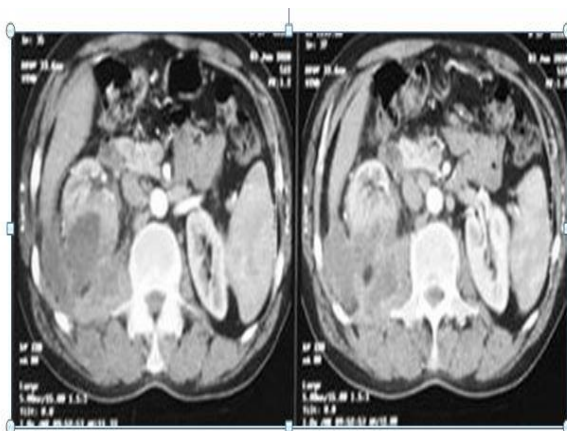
CT Scan showing renal abscess and perinephric abscess
